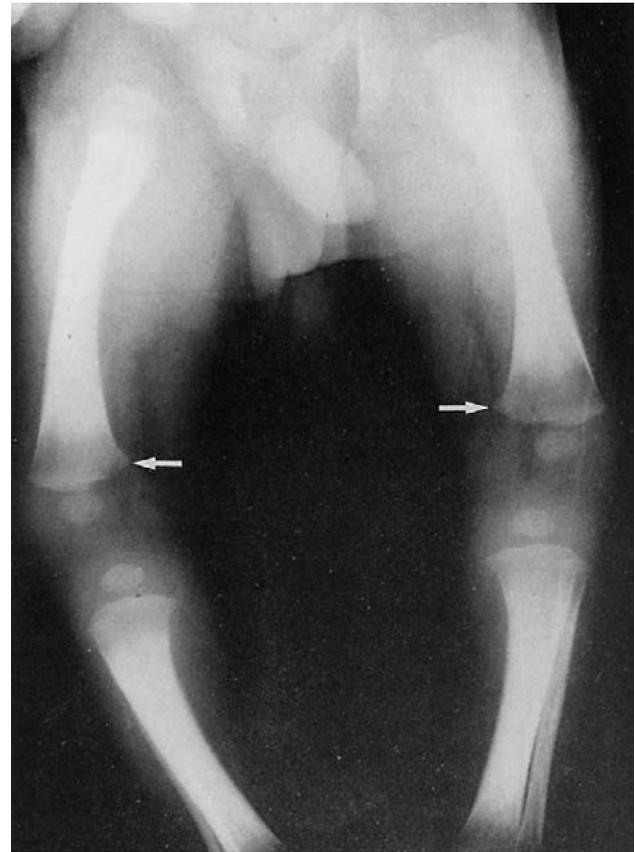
This radiograph of a 1 month old with craniometaphyseal dysplasia demonstrates sclerotic long bones with little marrow space seen in the diaphyses. It should be noted that there is already some clearing of the bone in the distal metaphyseal region of both femurs (arrows, which had been sclerotic at birth).
